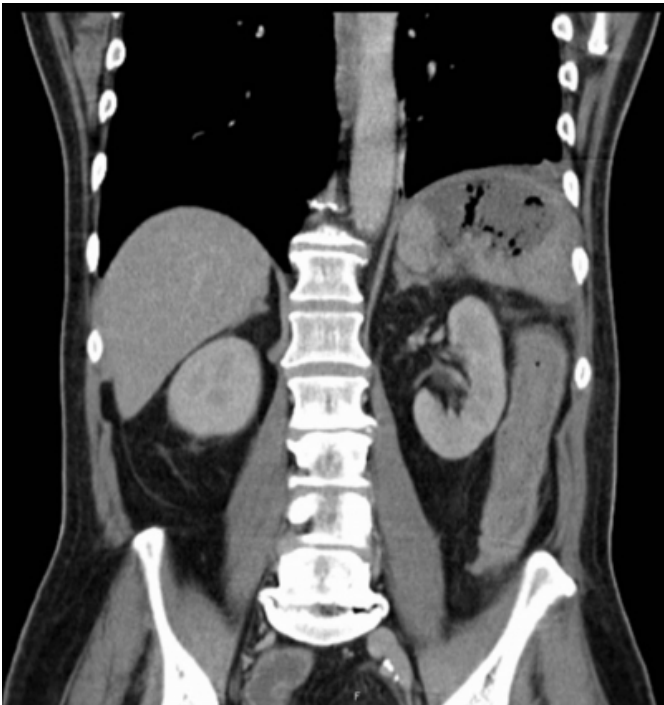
The frontal (A) and transversal (B) CT scans of the abdomen show the splenic abscess with gas-enclosures.
